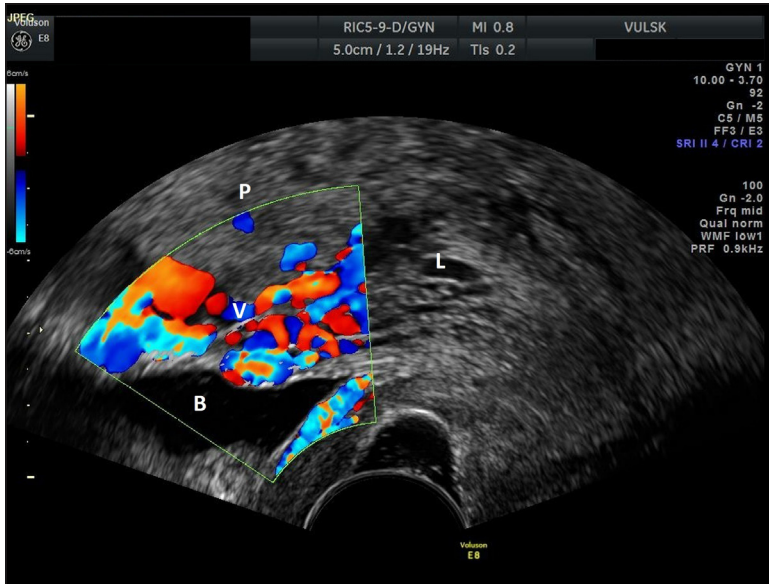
An ultrasound image in Doppler mode. Transvaginal probe. Lacunar spaces (L) of various size and irregular are present in the placenta (P). The posterior wall of the bladder (B) is convex. An active heterogeneous blood flow (V) is observed near the bladder and in the placenta
